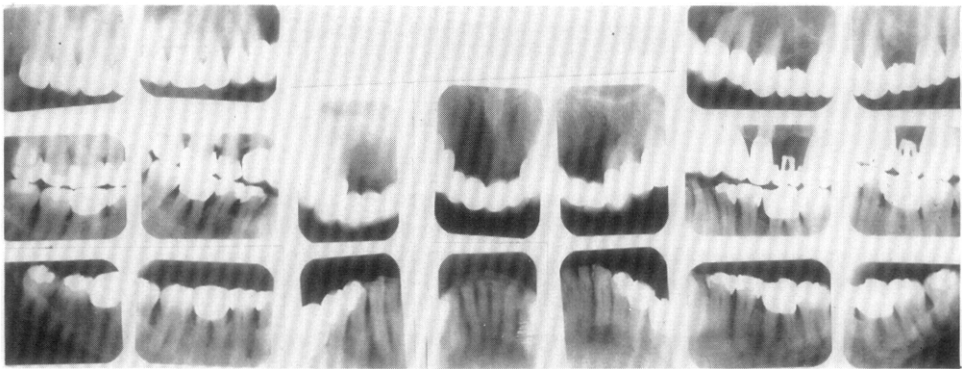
The use of the blade technique to rehabilitate the mouth of a 36-year-old woman: radiographs made in 1973. The upper anterior restoration was changed in 1970. Structures are excellent at age 67 after 31 years of service. (From Schweitzer, J. M.: Oral Rehabilitation, St. Louis, 1951, The C. V. Mosby Company, pp. 1101-1115.)
